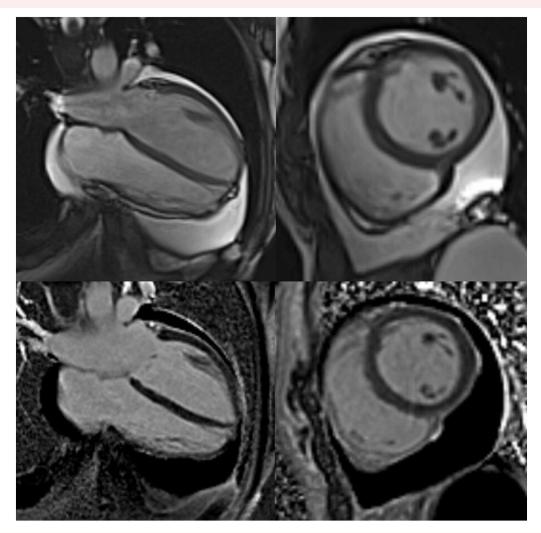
Cardiac magnetic resonance imaging at 4-month follow-up. In the first line, cine-steady-state free precession images (in four-chamber and mid short-axis views, respectively) show moderate residual pericardial effusion. In the line below,  $T_1$  phase-sensitive inversion recovery late gadolinium enhancement acquisitions confirm the presence of pericardial fluid without significant pericardial thickening or contrast enhancement.
